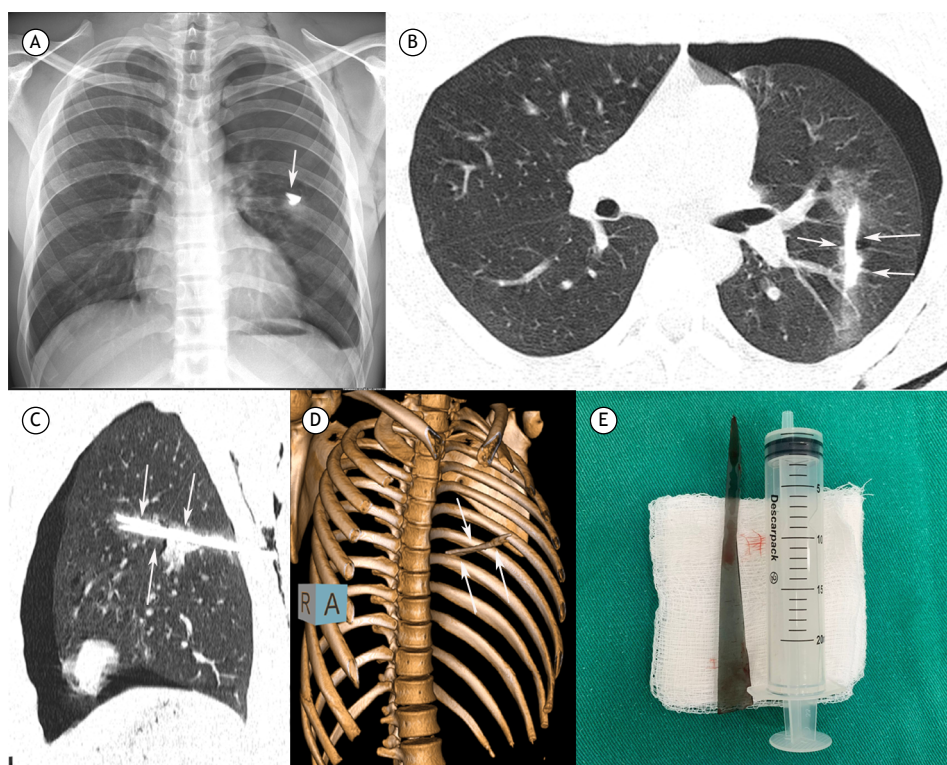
Chest radiograph (A) showing a dense foreign body in the left hemithorax (arrow). Axial (B) and sagittal (C) chest CT images and 3D reconstruction (D) demonstrating a dense linear foreign body in the left lung and ground-glass opacities (hemorrhage) in the periphery. Note also the pneumothorax on the left. (E) The mirror fragment removed from the patient, measuring about 30 cm.
